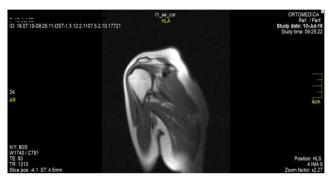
MRI scan done after the treatment
